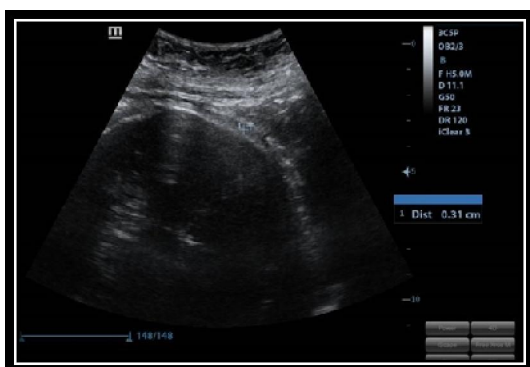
lower uterine segment by transabdominal ultrasound.
